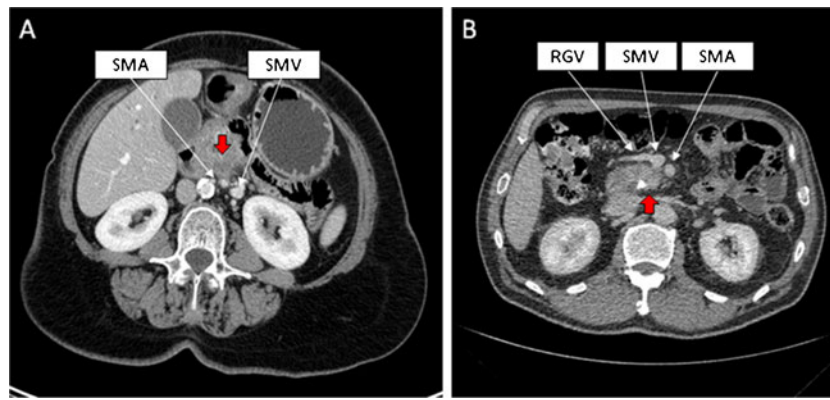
Examples of pancreatic ductal adenocarcinomas where the radiology report and intraoperative findings were discrepant, with regard to vessel involvement. a The CT scan suggests the presence of cancer around the SMA and would technically be a “borderline” PDA.²³ The report described a “pancreatic mass medially encasing the SMA by 150° with fatty infiltration.” The tumor was resected with negative margins. b No involvement was noted on CT, but clear
